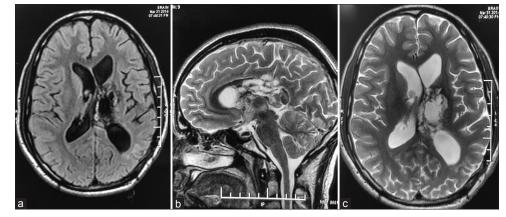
Contrast-enhanced magnetic resonance imaging showing residual tumor in (a) T2-weighted fluid-attenuated inversion recovery (axial view), (b) T2-weighted (sagittal view), (c) T2-weighted (axial view) images
